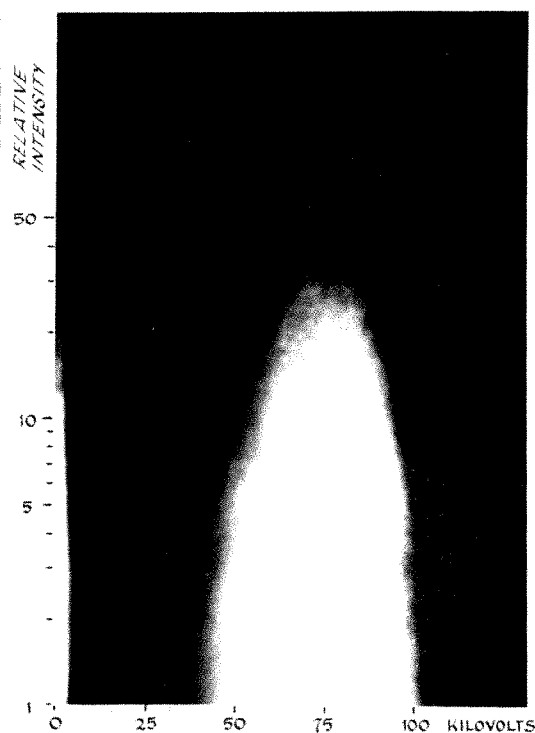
Energy distribution as presented by scintillation detector and pulse height analyzer. The roentgen-ray source was a tungsten target tube fed by an unfiltered full wave rectifier set at 100 kv. The beam was filtered by 0.5 mm. of aluminum and 7 m. of air. Approximately 4,000 quanta interacted with the detector in less than one half second. Detectors do not show perfect resolution, but in this energy range they are not troubled by Compton interactions or pair production. If more quanta are used to give a smoother curve then it should prove possible to employ an optical computer based on filtering spatial frequencies to correct the observed distribution for imperfect energy resolution.
